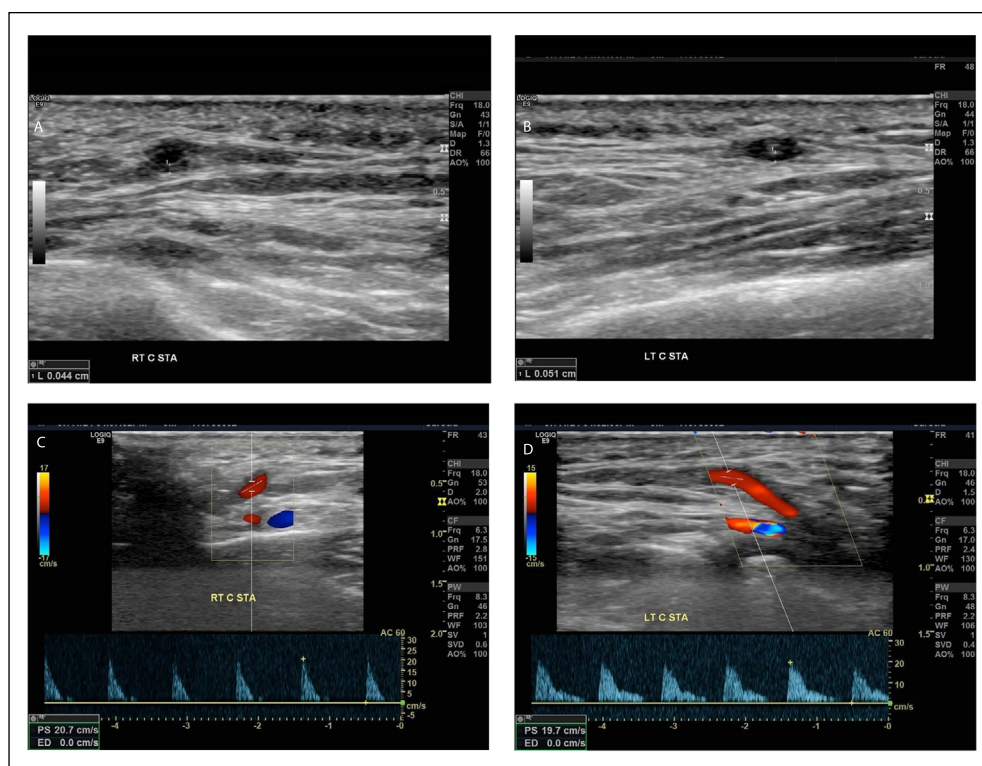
(A) No halo sign is seen in the right superficial temporal artery, (B) whereas a halo sign is present in the left common superficial temporal artery (wall thickness > 0.05 cm). (C, D) Flow velocities are remarkably decreased in both vessels; color Doppler mode increases the visibility of the thickened hypochoic vessel wall.
